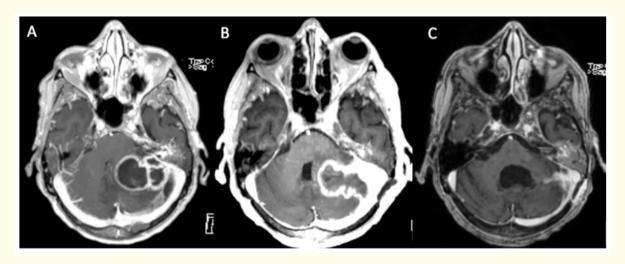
A: Pre-operative MRI with contrast showing a large multilobulated abscess in the left cerebellopontine angle with severe compression of the left cerebellum and brain stem. There is also contrast-enhancement of the left pars petrosa and left internal acoustic meatus. B: MRI with contrast 19 days following surgery showing slight regression of the abscess and less compression of the posterior fossa. C: MRI with contrast 4 months following surgery showing almost absolved abscess and no compression of the elements in the posterior fossa.
